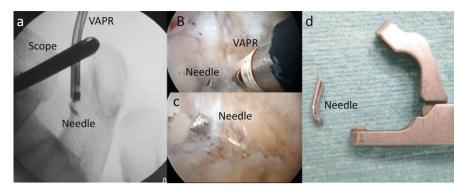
Breakage of a suture punch needle. (a) Breakage of needle in the rotator cuff was confirmed under X-ray fluoroscopy, and the rotator cuff was ablated using VAPR, toward the direction of the existing needle. (b) A portion of the needle was confirmed under arthroscopy after ablation of the rotator cuff by VAPR. (c) The needle was exposed and removed using curette forceps. (d) The suture punch and the broken needle are shown
